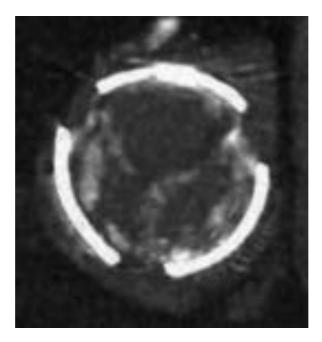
Severe calcifications of a bioprosthetic aortic valve (non- contrast CT image)
